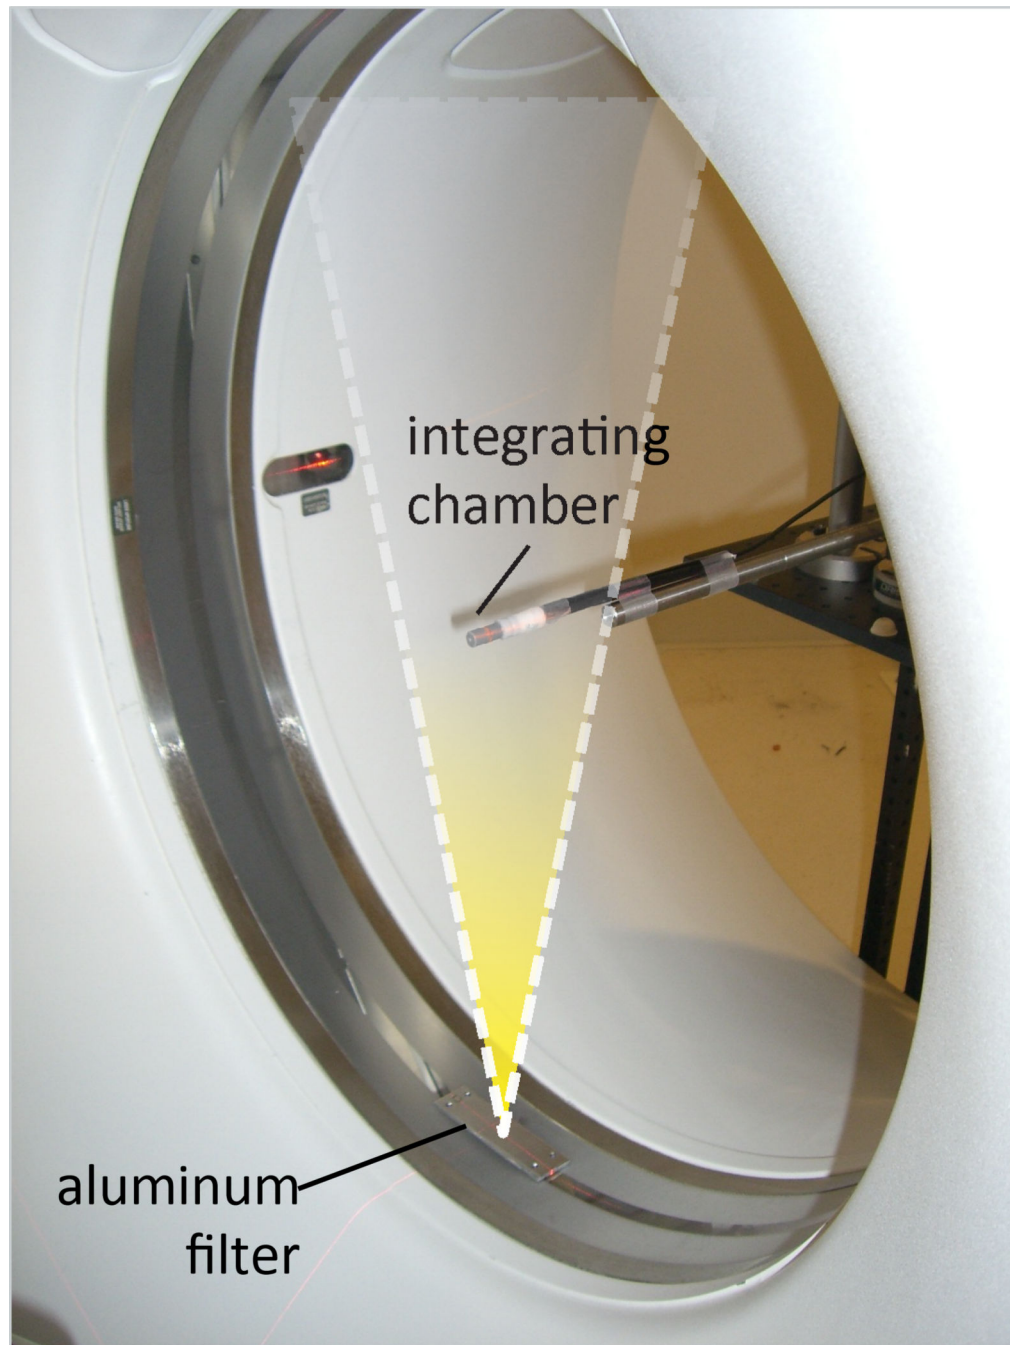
Photograph of the system set up for the conventional HVL measurements. The aluminum filters from the AAF were removed and placed on the bottom of the CT gantry so that they attenuated the incident x-ray (held stationary at the 6 o'clock position). A 0.6 cc integrating air ionization chamber was placed at the laser-indicated isocenter.
